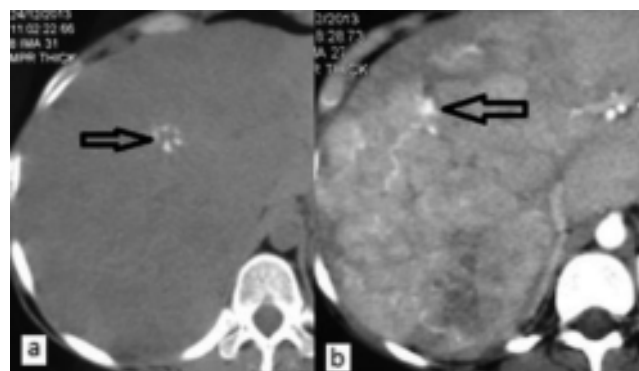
(010) CT without (A) and with contrast (B) when hypervascular liver tumor, calcified central scar is observed (arrows).
